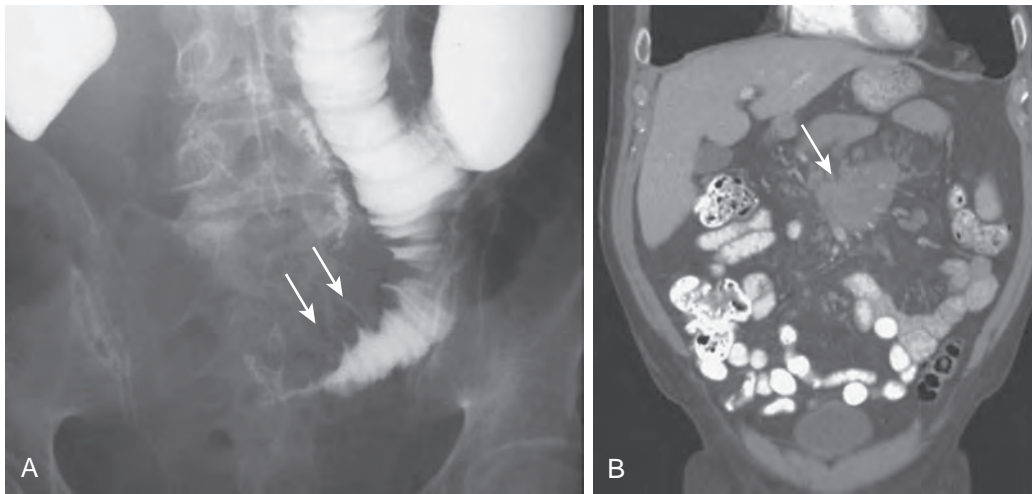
Mesenteric seeding of tumor. A. Malignant seeding down the small bowel mesentery from a gastric carcinoma is causing obstruction and spiculation of the valvulae conniventes (arrows) on the mesenteric side of the jejunum. B. Coronal reformatted CT image shows a carcinoid tumor infiltrating the root of the small bowel mesentery (arrow).
